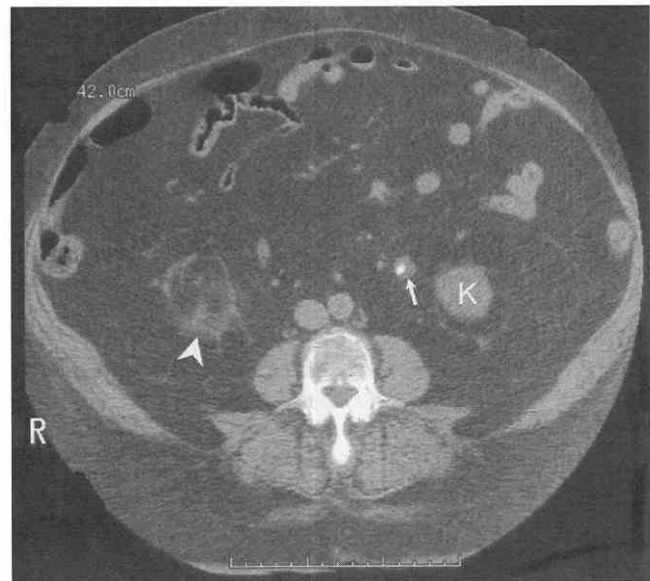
Non-contrast renal CT protocol. Axial image demonstrates a left ureteric calculus with surrounding ureteric wall edema called the soft tissue rim sign (arrow). Part of the left kidney (K) is seen. There is some right perinephric edema (arrowhead) because the patient had bilateral ureteric calculi (not shown).
